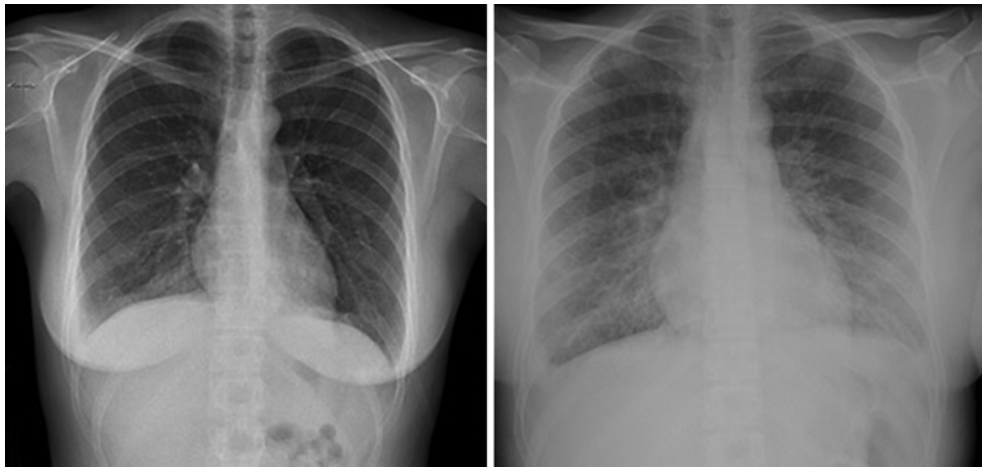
Chest radiography at admission (left) and 4 days after admission, developing APE (right).
